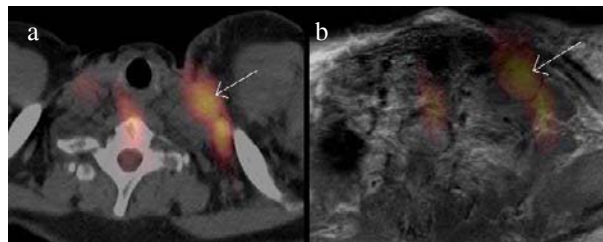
(a) PET/CT fusion; (b) PET/MRI fusion
